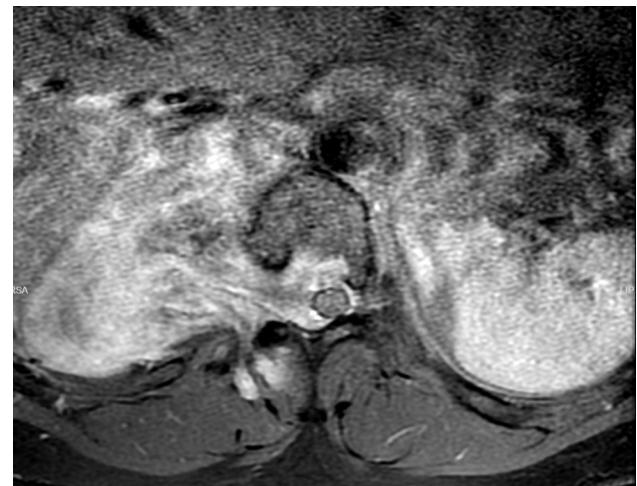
Contrast-enhanced axial T1-weighted magnetic resonance image showed intense enhancement of the tumor that enlarged the neural foramen and extended to the spinal canal. The mass compressed the spinal cord.
